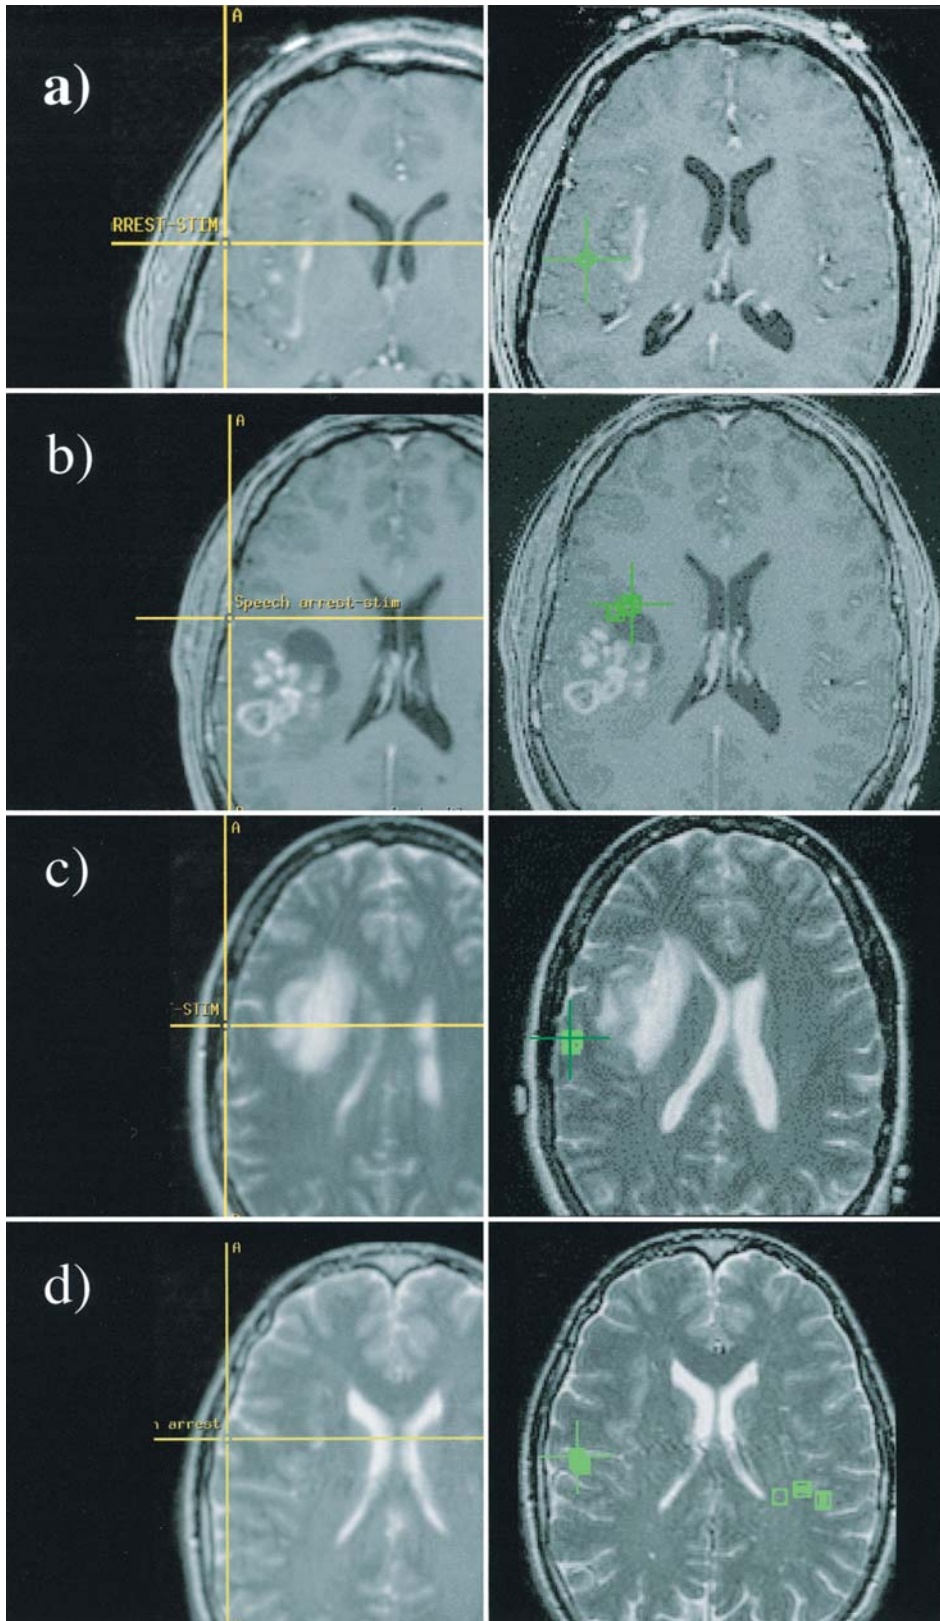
Axial MR images. *Left*: Preoperative MR slices on which the stimulation-mapped sites of speech arrest (yellow crosshairs) were recorded intraoperatively. *Right*: Corresponding slices with late MEG modeled current dipole sources (green) superimposed. The green crosshairs indicate the source closest to the intraoperative essential language site. Rows indicate data obtained in separate patients. a: Case 10. A cluster
